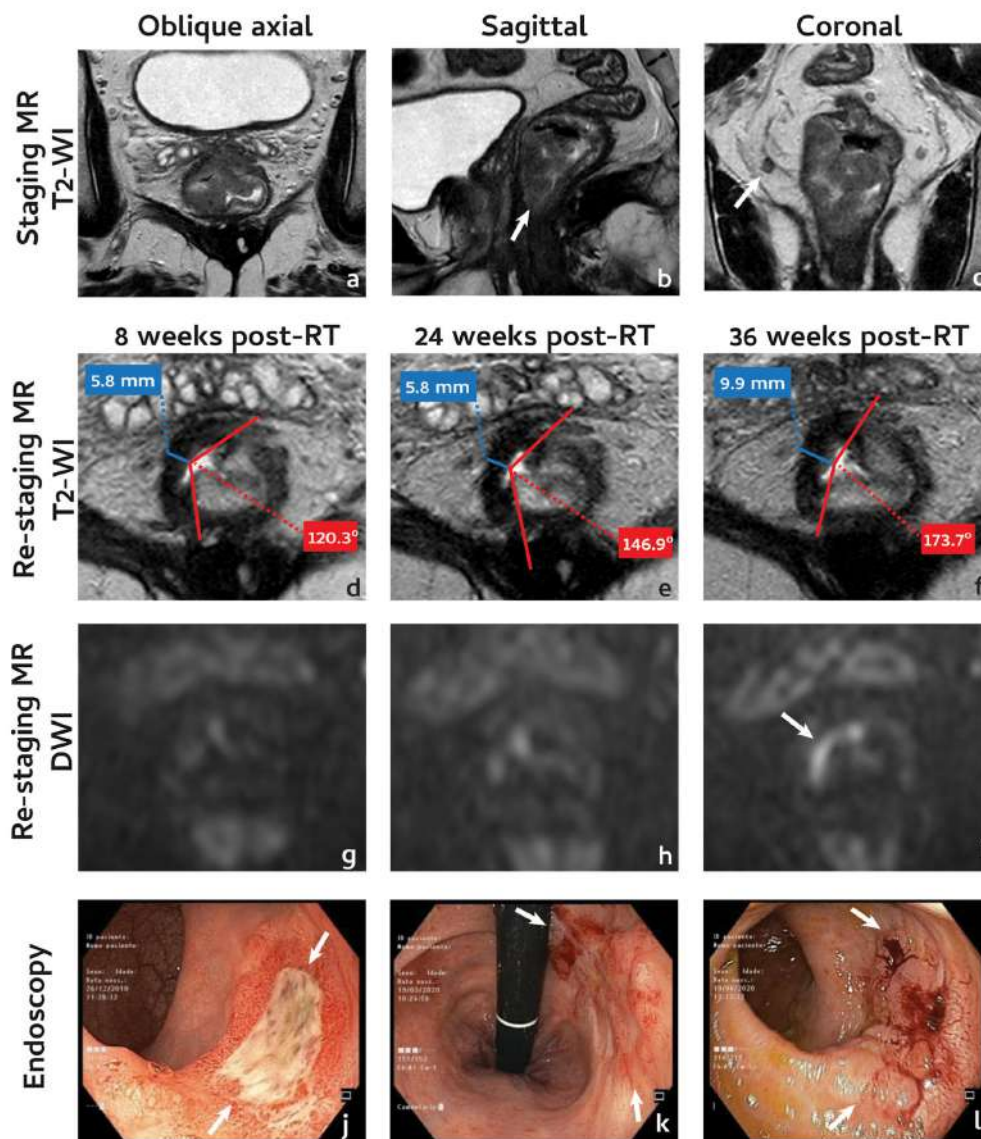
Forty-two years old male with a low rectal cancer, mrT2 mrN1 EMVI- MRF-. Tumour was located anteriorly and abutted the anorectal transition (arrow in b). A positive lymph node is depicted in c (arrow). Patient underwent CRT + adjuvant CT. At first assessment, response was graded mrTRG2 (d), negative on DWI (g) and grade 3 on endoscopy (j). At second assessment, mrTRG and DWI remained stable (e,h) but the scar lost its concavity (+26.6°) (e). Scar thickness did not change (e). On endoscopy, an adenomatous residual mucosal abnormality (grade 2) was observed (k). At 36 weeks of follow-up, intermediate tumour signal became apparent on the endoluminal surface of the scar (f), DWI became positive at the same location (i) while scar thickness and angle further increased (f). Patient underwent an AAP and was staged as ypT2N0R0.
